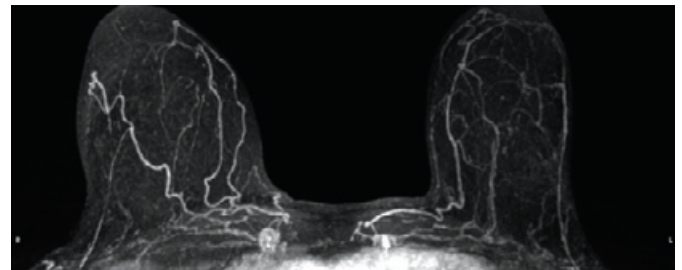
Breast MRI - 3D image, normal study.
